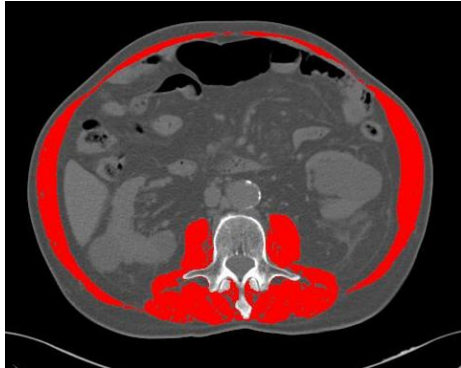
Processed Computed Tomography image at third lumbar vertebrae for body composition assessment. Psoas, paraspinal muscles, quadratus lumborum, rectus abdominis and obliques are segmented together with a red tag. Visceral, subcutaneous, and intramuscular adipose tissue are depicted in yellow, blue, and green tags, respectively.
